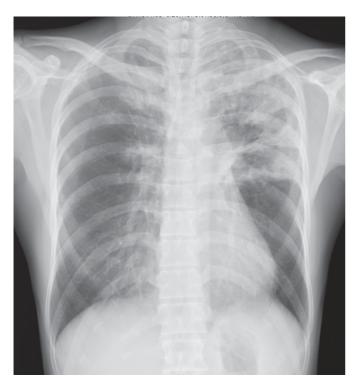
Chest X-ray on admission shows left-dominant consolidations in bilateral upper lung.
